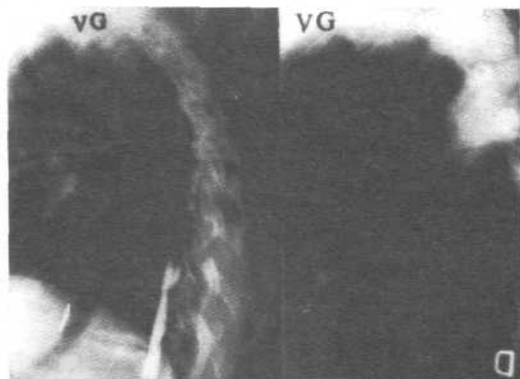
V.G., female, 62 years old, vascular pedicular rib graft, solid fusion on follow up x-rays.
